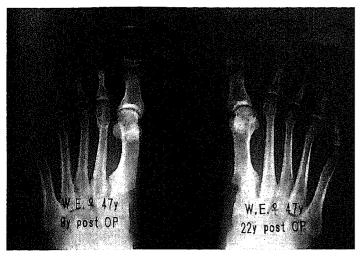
Patient 16. Radiographs were obtained 22 years after primary surgery and 9 years after correction on the left side. There was a varus deformity of 12° on the right side and 4° on the left side.
